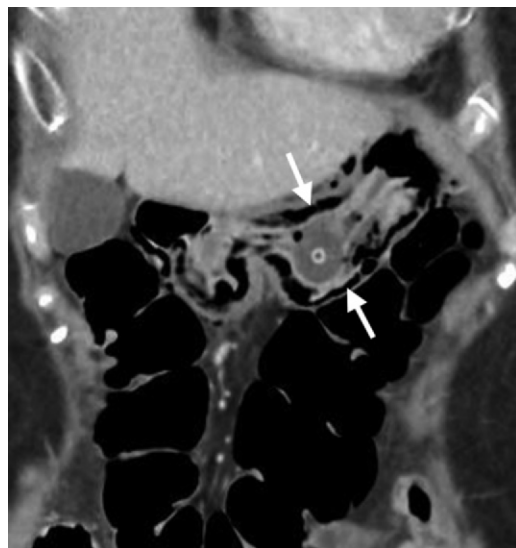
Gastric emphysema in an asymptomatic patient with recent gastrostomy tube placement. Coronal CT image demonstrates air (arrows) in the gastric wall and a gastrostomy tube balloon. Note the lack of gastric wall thickening.
